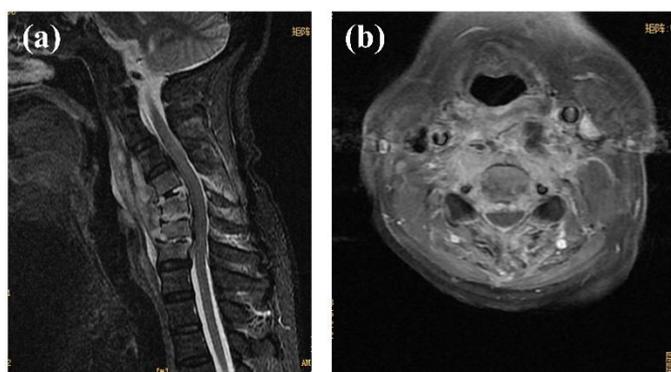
Enhanced MRI shows multiple bone marrow edema in the C4-7 vertebral body and appendages (C5 and C6 move backward relative to the lower vertebral body), and long T2 signal can be seen in the corresponding intervertebral space. Strips of T1 and long T2 signals can be seen at the back of the vertebral body and at the front edge of the vertebral canal, resulting in the narrowing of the vertebral canal and slight compression of the cervical spinal cord. The soft tissue in front of C1-T1 vertebral body swelled, mixed signals were shown on T1WI and T2WI, involving bilateral musculus longus colli, and the left side was marked. The
